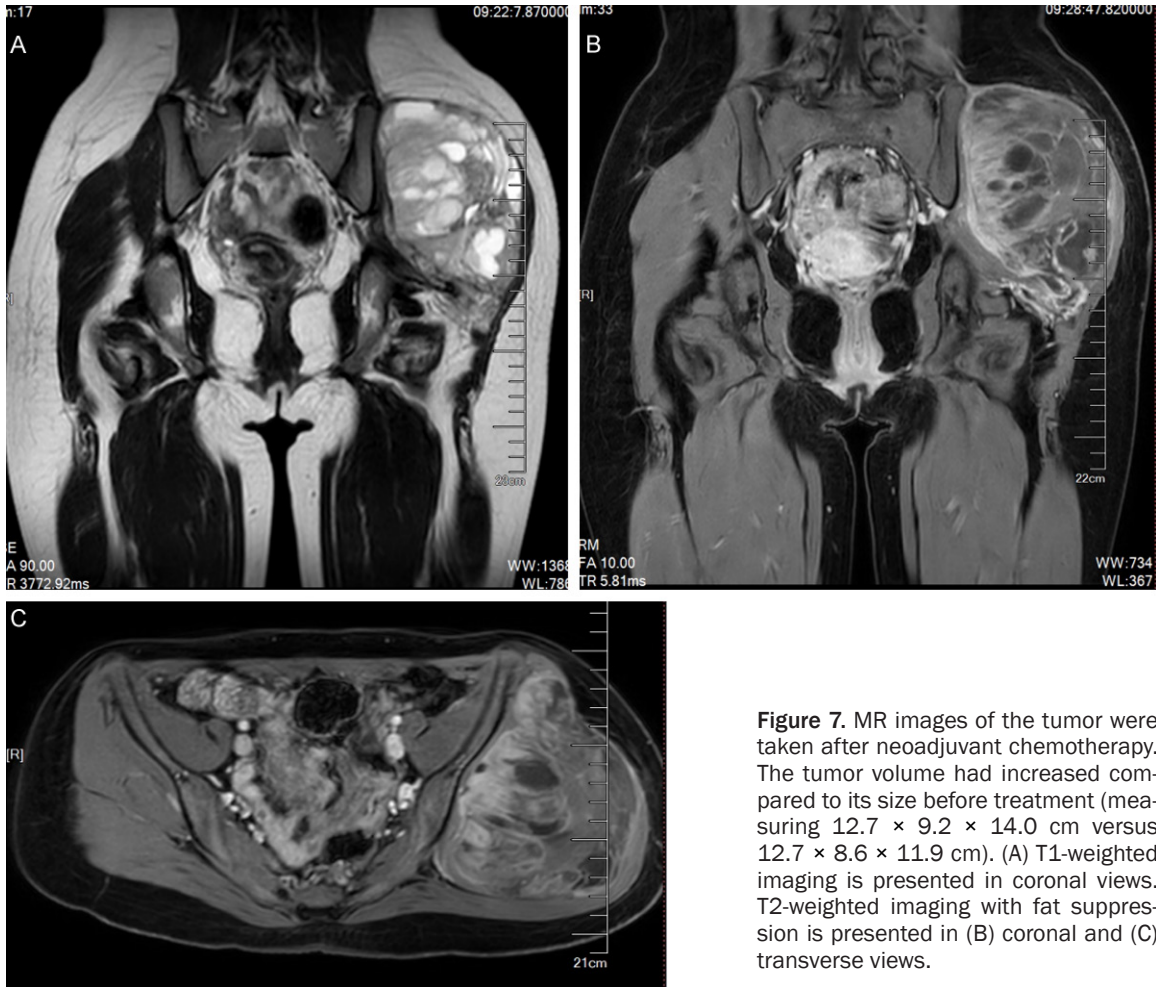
MR images of the tumor were taken after neoadjuvant chemotherapy. The tumor volume had increased compared to its size before treatment (measuring 12.7 × 9.2 × 14.0 cm versus 12.7 × 8.6 × 11.9 cm). (A) T1-weighted imaging is presented in coronal views. T2-weighted imaging with fat suppression is presented in (B) coronal and (C) transverse views.
